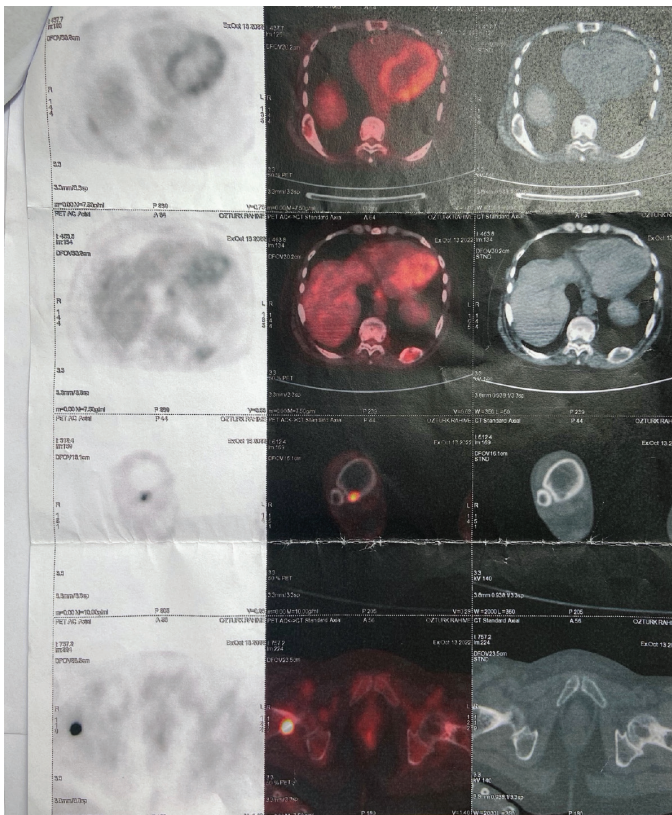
The patient was found to have a lesion in the intramedullary area with mild FDG uptake, and based on the trucut biopsy of lytic bone lesions, the lesions present in the left 10th and right 9th ribs appear to be consistent with brown tumors
